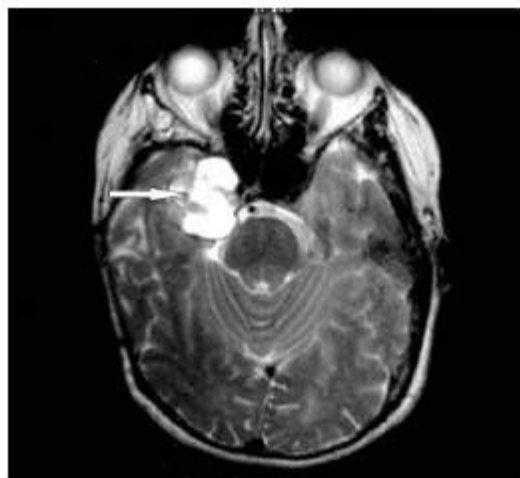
Axial T2- weighted MRI scan with gadolinium DTPA contrast showing atypical enhancing trigeminal neuroma located in the middle cranial fossa.
